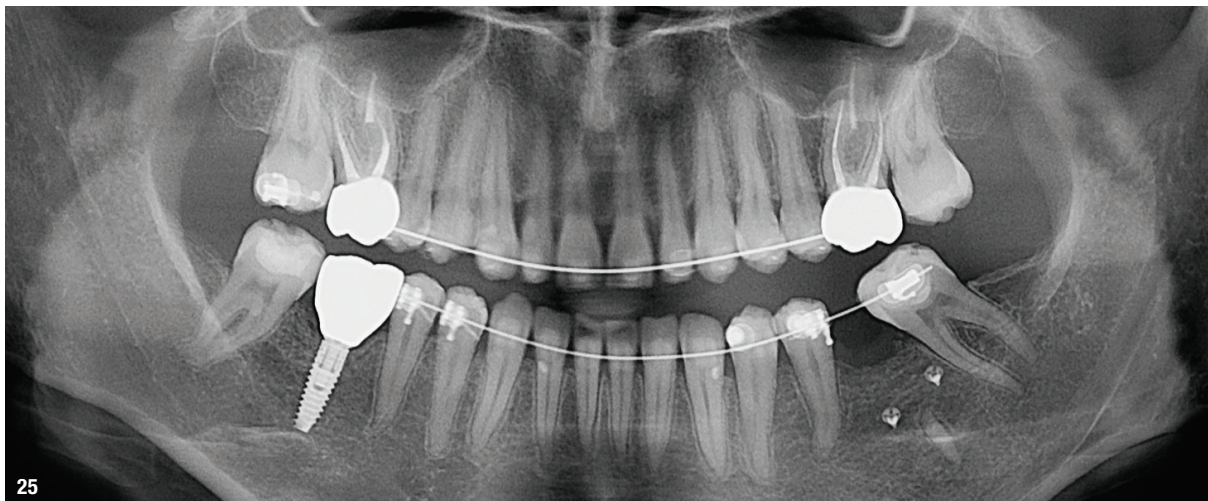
Panoramic radiograph at 36 months post-op.
